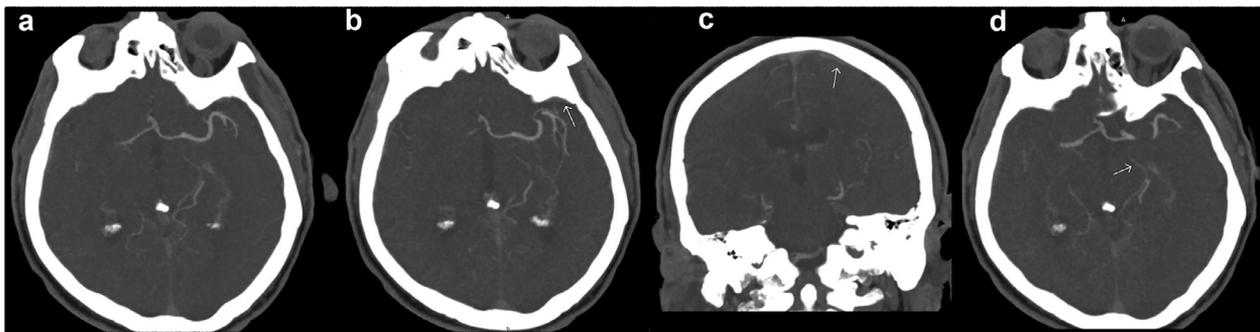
(a) CTA demonstrating right M1 occlusion in the case described. There was partial filling of the contralateral superficial middle cerebral vein (b), complete filling of the contralateral vein of Trolard (c), and partial filling of the contralateral basal vein of Rosenthal (d). Arrows indicate the described contralateral veins. Partial filling of the ipsilateral vein of Trolard and basal vein of Rosenthal were present. Abbreviation: CTA, computed tomography angiography.
